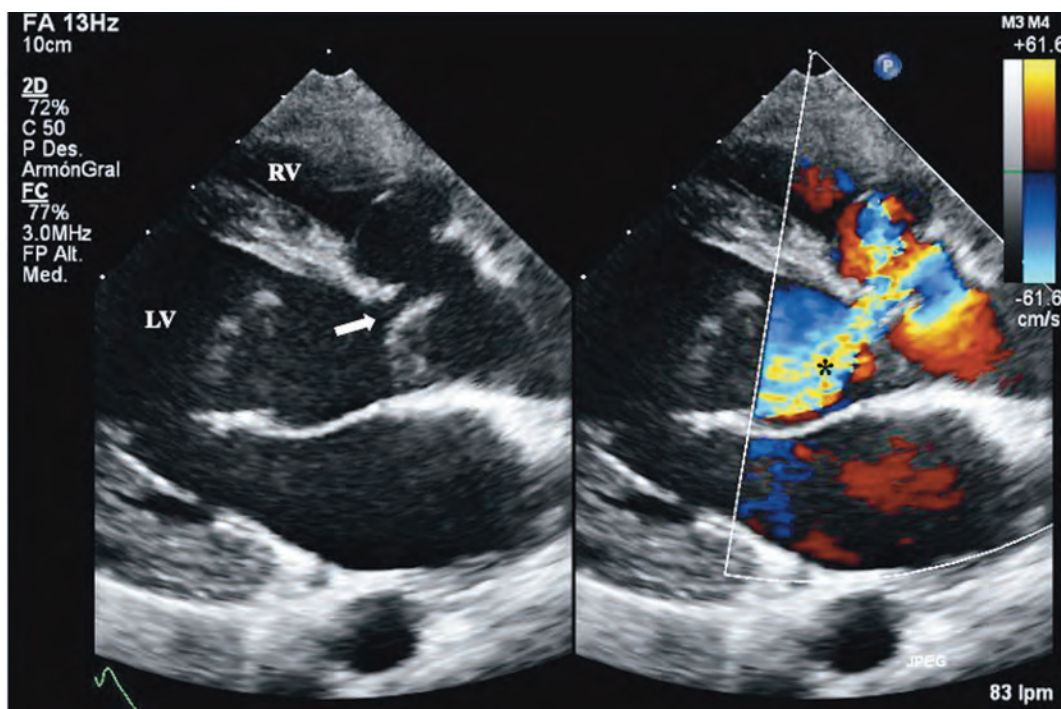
Transthoracic echocardiogram shows the ventricular septal defect (arrow) and aortic regurgitation (*). LV: left ventricle; RV: right ventricle
